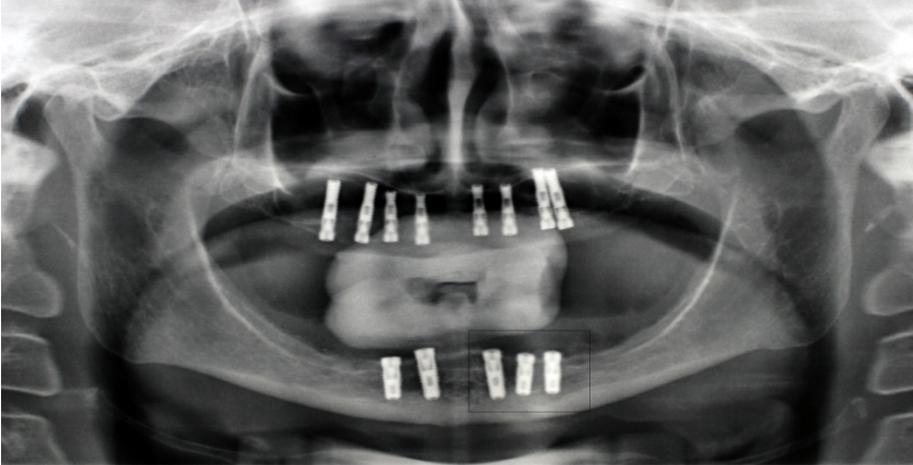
The panoramic x-ray picture at the time of Wi.tal implants placement
